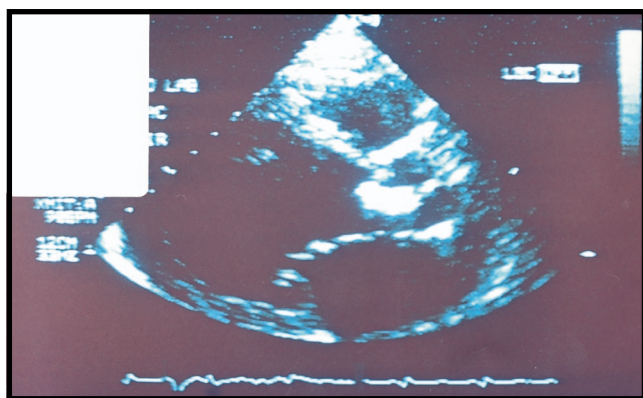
Transthoracic echocardiogram long axis view of vegetation on the aortic valve.
